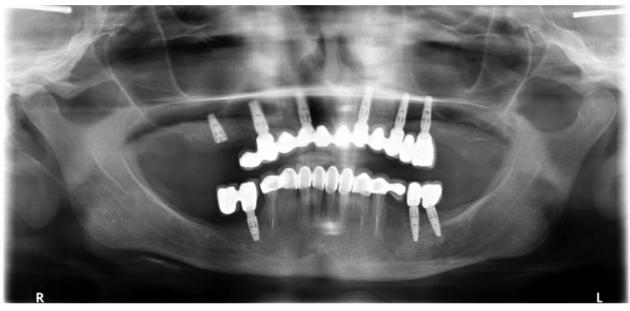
Panoramic x-ray after two years recall Rycina 11. Zdjęcie radiologiczne panoramiczne po dwóch latach obserwacji
